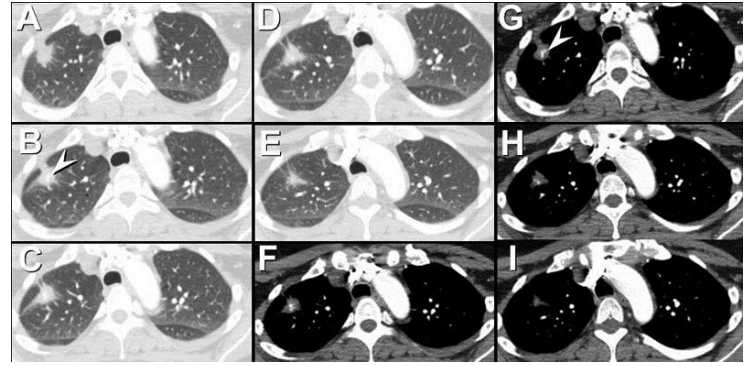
Axial enhanced chest CT displayed in lung (A-E) and soft tissue (F-I) windows shows a spiculated apical nodule with a pleural tail. The lesion contains a small focus of calcium (arrowheads).
